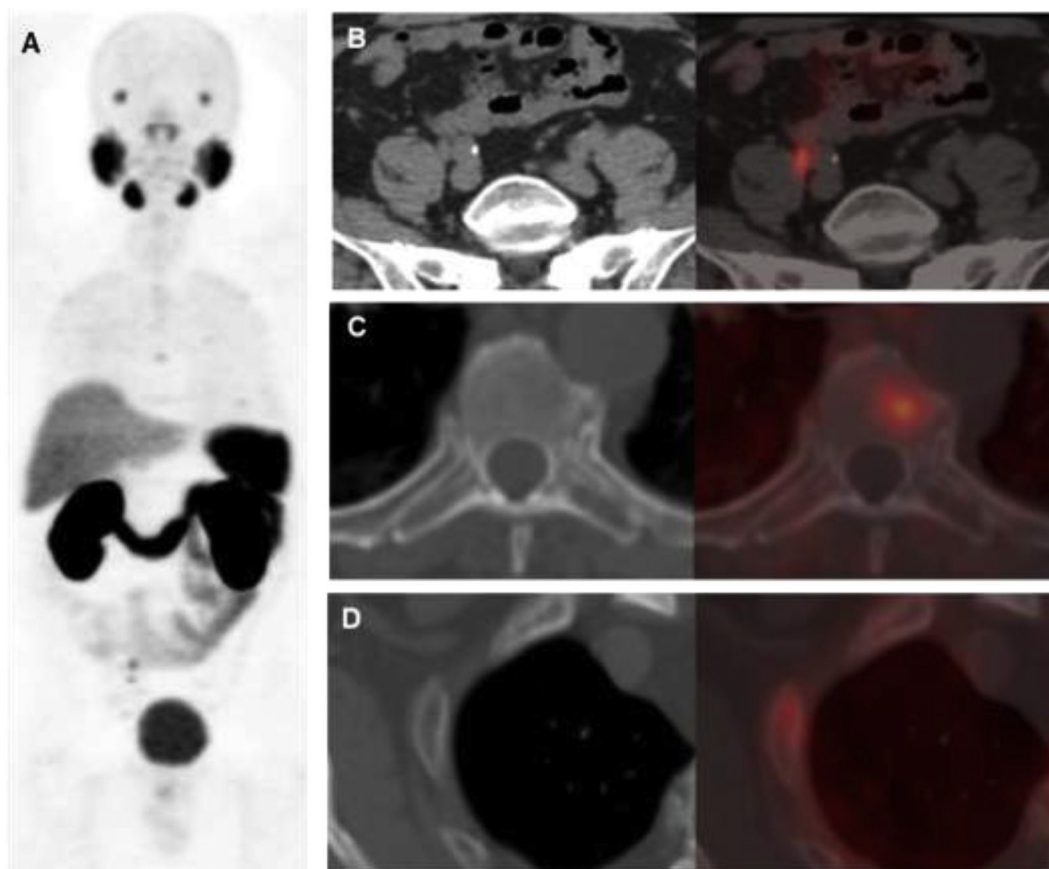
A 69-year-old patient with a history of stage T3b N0 M0 prostate adenocarcinoma, Gleason 7 (4 + 3), treated with surgery and radiotherapy two years ago, and one-year of intermittent hormonotherapy. The patient presents elevated PSA levels (current: 1.64). No evidence of disease on CT, MRI, or 18 F-Fluorocholine PET-CT. ^{68}Ga -PSMA PET-CT is performed: (A) coronal MIP image; (B, C and D): axial CT and PET-CT images. Subcentimetric nodal lesions were observed in the right common iliac chain, with bone lesions in the spinal column and rib cage, and PSMA overexpression. The bone lesions are not visible on CT.
